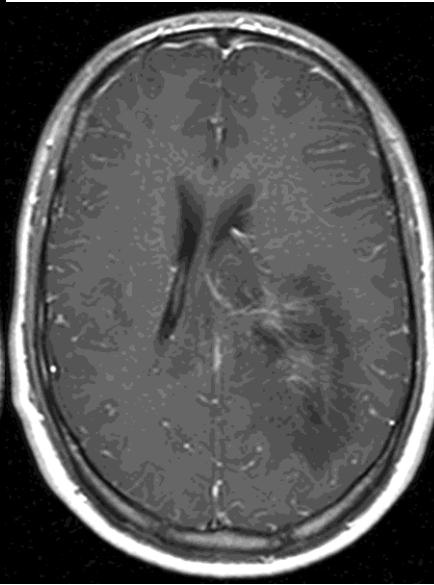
MRI-E, the INTERPRET DSS and MRS-E results for Case 4, an Astrocytoma WHO grade III.
